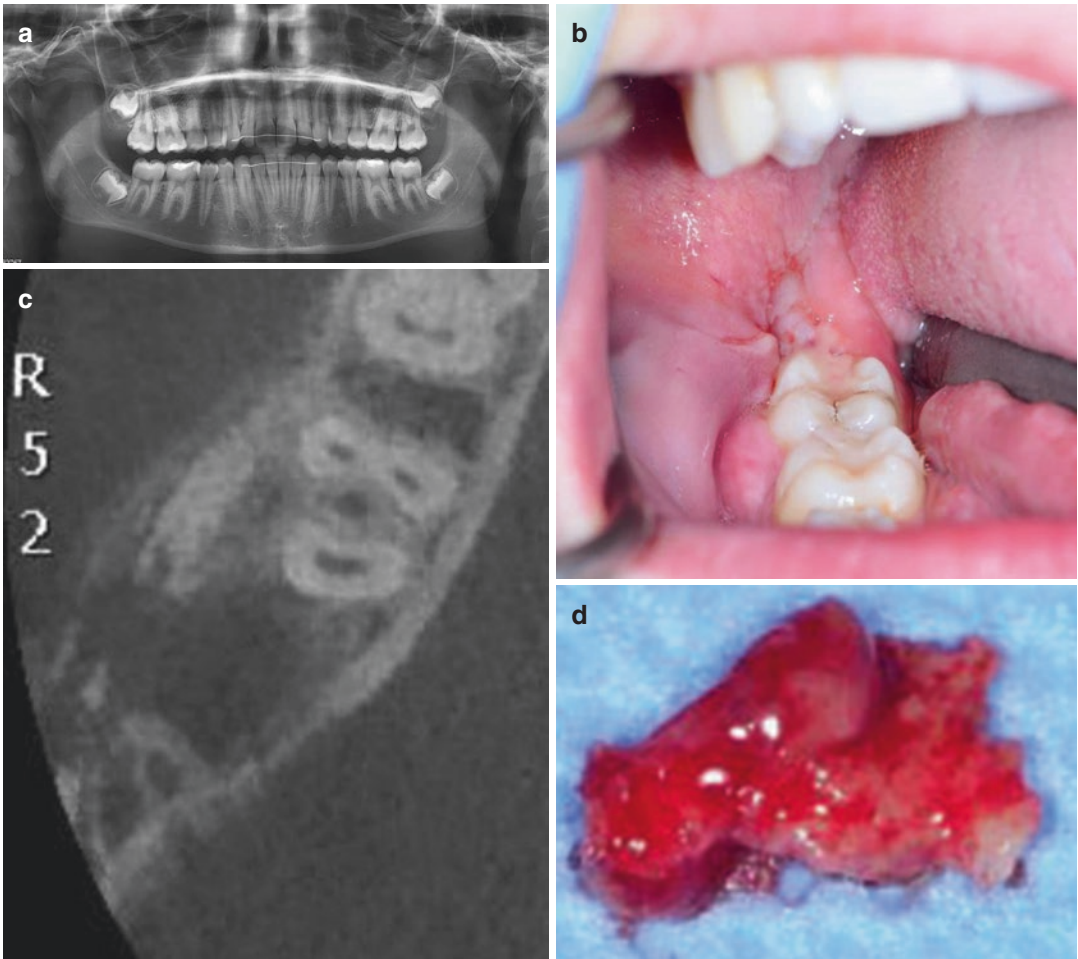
(a) Chronic infection and beginning osteomyelitis after wisdom tooth removal on panoramic radiograph. (b) Exploration of the wound revealed a large necrotic bone sequester with chronic swelling. Removal of all
